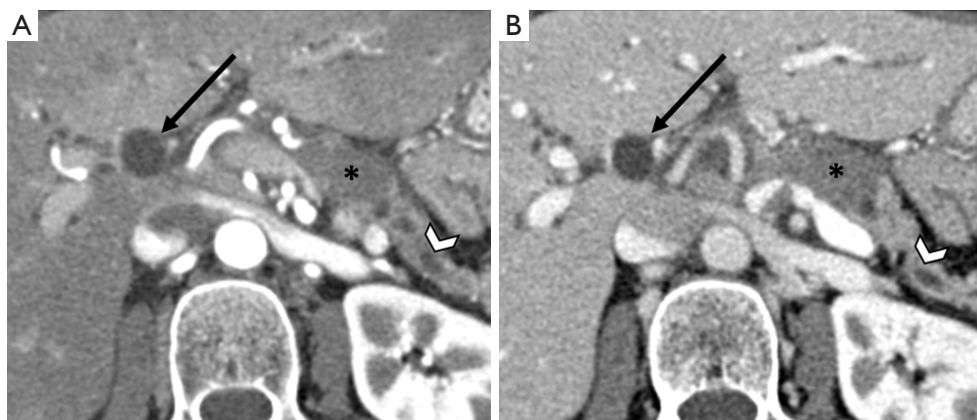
CT of pancreas body mass. Axial (A) arterial and (B) portal venous phase CT in a 53-year-old woman demonstrates a 4 cm hypodense pancreas body mass (asterisk) which causes pancreatic duct (chevron) and mid common bile duct dilatation (arrow). CT, computed tomography.
